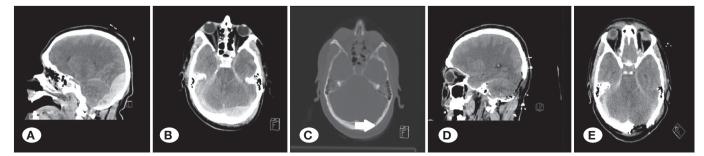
Preoperative CT of case 16 A-B) sagittal and axial CT scan revealed epidural hematoma C) Linear skull fracture D-E) Postoperative sagittal and axial CT scan revealed evacuation of epidural hematoma.
